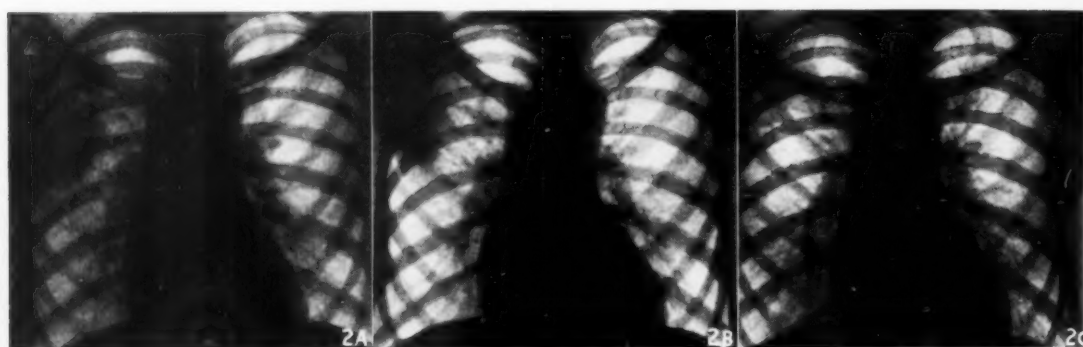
C.N., Native male, 34 years. Penicillin, $2\frac{1}{2}$ mega-units over 5 days. Sulphadiazine, 48 g. over 9 days. Worked as garden boy from commencement of treatment. Symptom-free in 24 days. Scar on X-ray in 57 days. Follow-up plate a year later showed no change.
